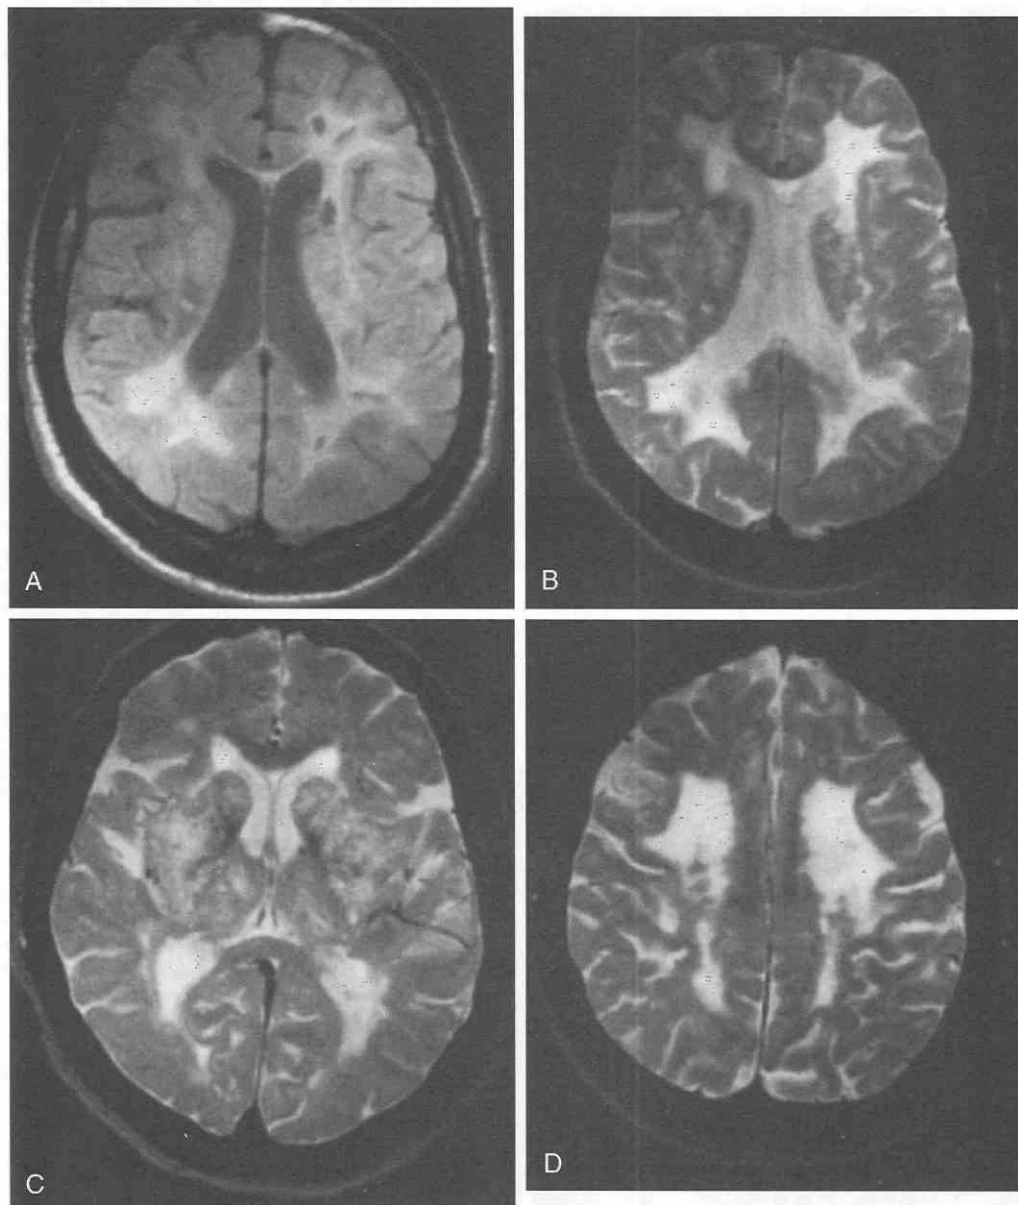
Familial arteriopathic leukoencephalopathy in two family members who were nonhypertensive with dementia. Cranial MR images are shown. Cerebral autosomal dominant arteriopathy with strokes, ischemia, and leukoencephalopathy (CADASIL) was confirmed at autopsy. *A* and *B*, Proton-density and T2-weighted axial images of diffuse symmetrical demyelination with cystic components in a 52-year-old man. *C* and *D*, T2-weighted axial MR images demonstrate extensive cribriform hyperintense signal in the basal ganglia and confluent demyelination in the centrum semiovale in a 70-year-old woman.
